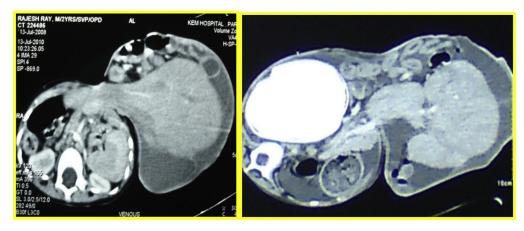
CT scan following intra abdominal tissue expander inflation.
